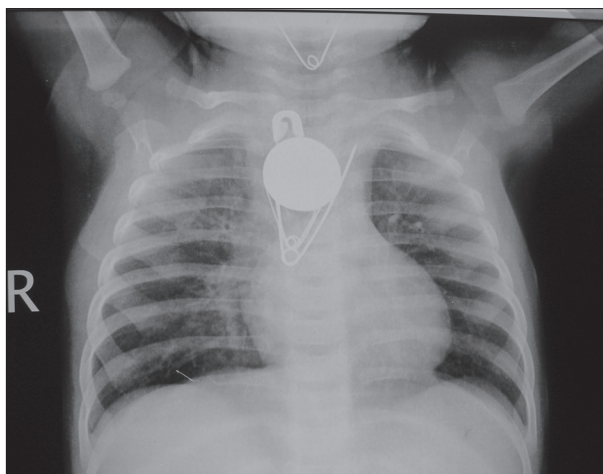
Chest X-ray, anteroposterior view, showing four open safety pins and one mid-thoracic coin
